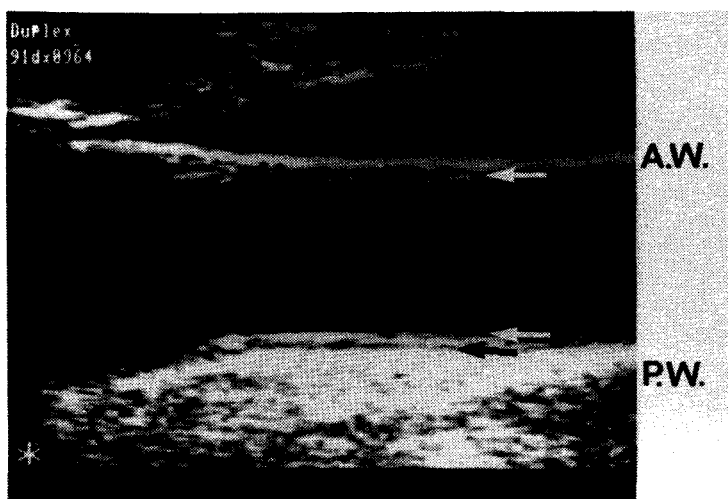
Characteristic longitudinal 2-D ultrasound image of the distal common carotid artery. AW = Anterior (near) wall of the carotid artery; PW = Posterior (far) wall of the carotid artery. Arrows from top to bottom indicate the leading edge of the intima-lumen interface at the near wall, the lumen-intima interfaces and the media-adventitia interface at the far wall, respectively.
